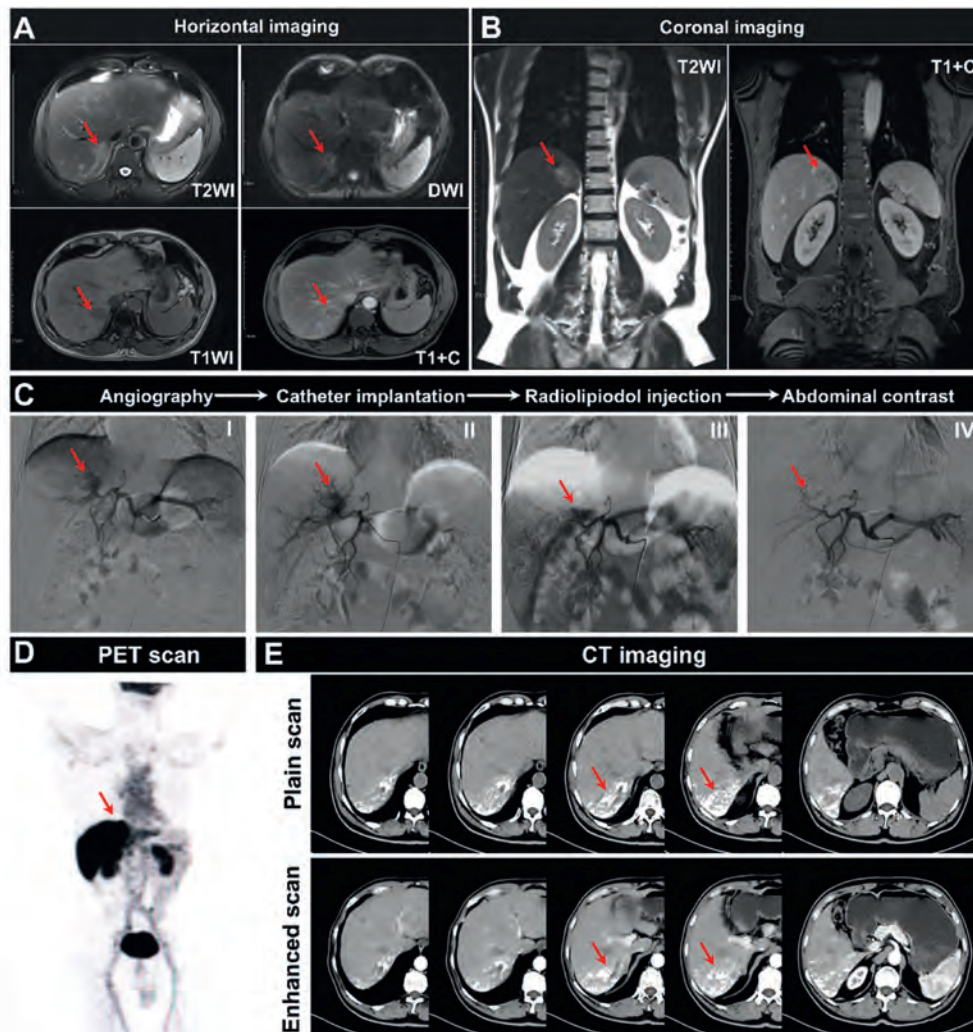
Stability studies of radiolipiodol in case 1 of HCC. (A) MRI horizontal plane image of case 1. (B) MRI coronal image of case 1, the red arrow indicated the lesion area of the liver cancer. (C) DSA-guided hepatic artery embolization in case 1, including I: tumor angiography, II: the microcatheter traveled to the main tumor feeding artery under the guidance of DSA, III: injection of ^{18}F -LUF(S), and IV: abdominal contrast after ^{18}F -LUF injected, the red arrow indicated the lesion area of the tumor. (D) PET scan of case 1 at 1 h after ^{18}F -LUF injection. (E) CT scan of case 1 on the 21st day after ^{18}F -LUF injection.
